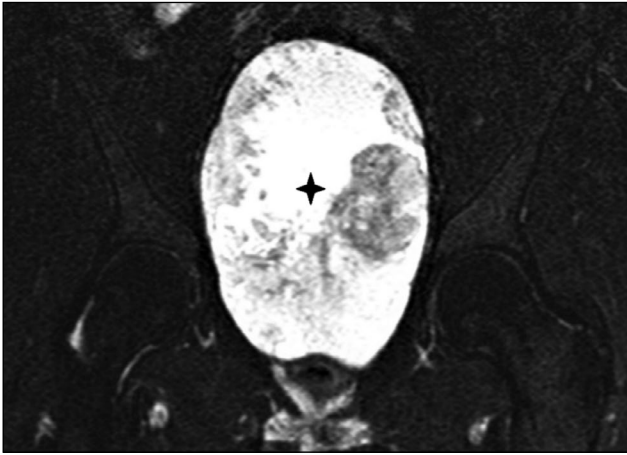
T2 SPAIR coronal MRI showing a heterogeneously hyperintense tumor occupying a significant portion of the pelvic cavity (asterisk). Pronounced heterogeneity of the signal is due to areas of hemorrhage.
